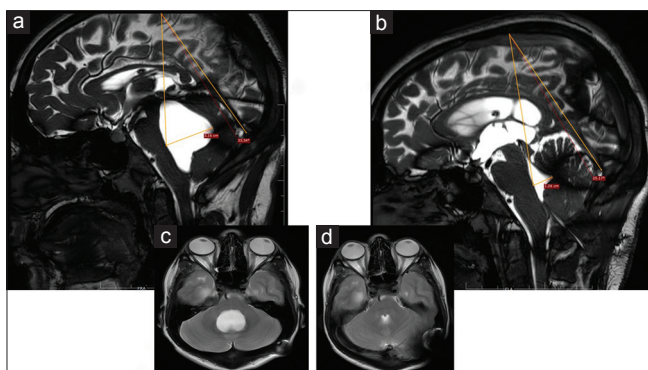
(a and b) Sagittal magnetic resonance imaging T2-weighted images. The brainstem tentorial angle change from 33° (preoperative) to 25° (postoperative). (c and d) Axial T2-weighted magnetic resonance imaging images at the mid-pontine level
